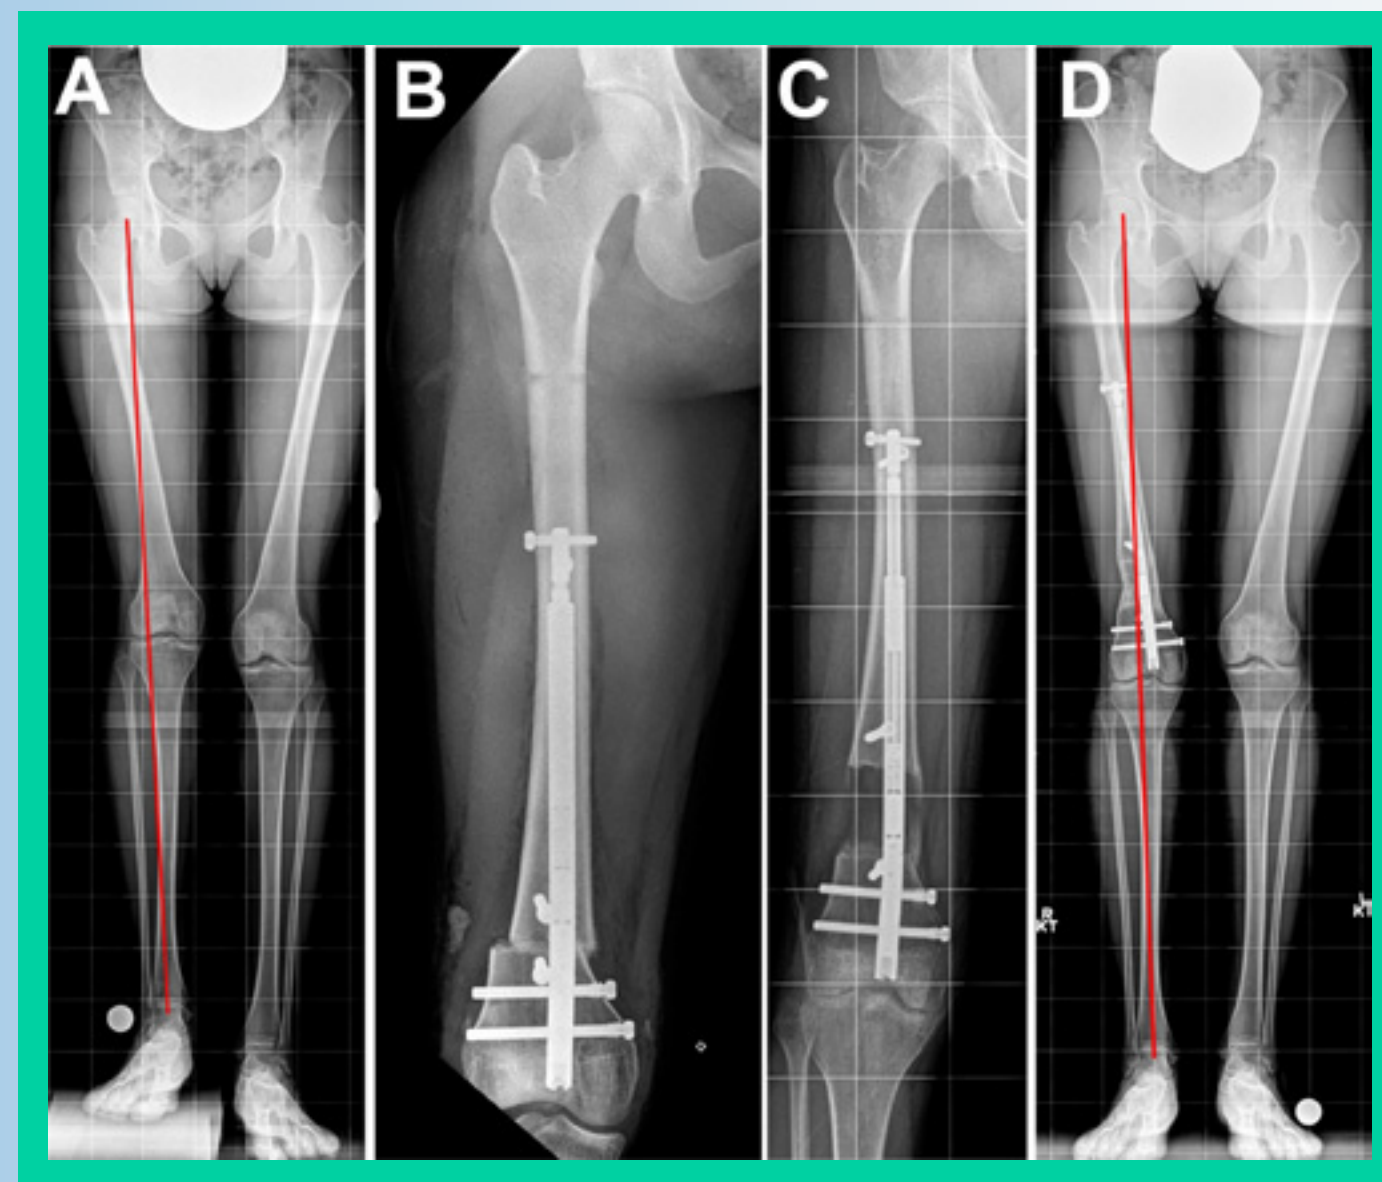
Twenty-year-old female with congenital femoral deficiency of the right limb. A, 4.5-cm femoral discrepancy with 11° distal femoral valgus deformity (lateral MAD). B, Radiograph obtained immediately after retrograde acute deformity correction and insertion of lengthening nail. Two blocking screws help to prevent valgus. C, Radiograph obtained after complete distraction was achieved. D, Radiograph shows regenerate consolidation, equalized limb lengths, and corrected limb alignment.
